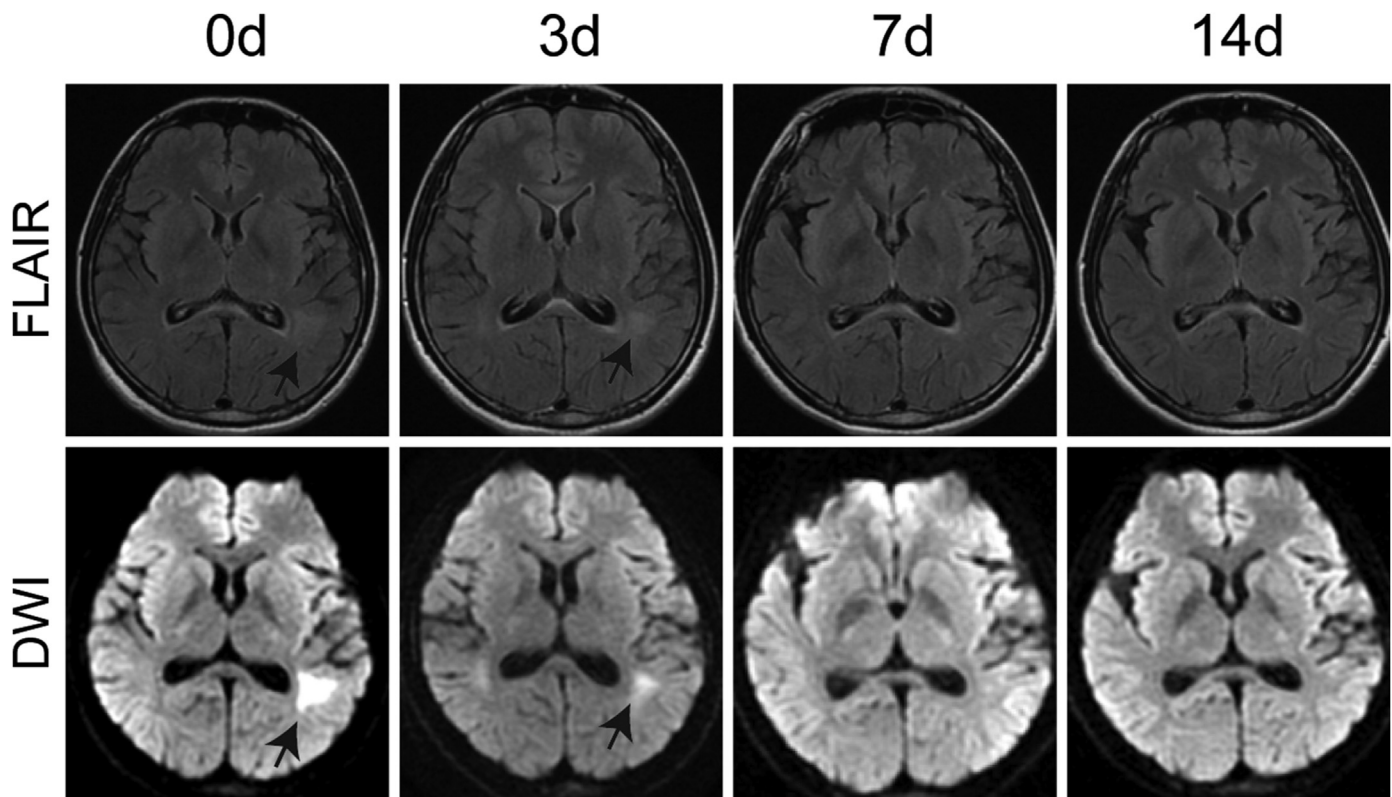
MR imaging of patient 2. On admission, the left frontotemporal parietal occipital lobe had high FLAIR abnormal signals, lesions showed diffuse restricted changes on DWI. After 3 days of treatment, lesions in the diffuse white matter and entire corpus callosum could be seen high FLAIR abnormal signal with unclear margins, and high signal on DWI. After 7 days of treatment, the lesions had basically recovered, as seen on DWI. On day 14, the lesions had resolved completely.
